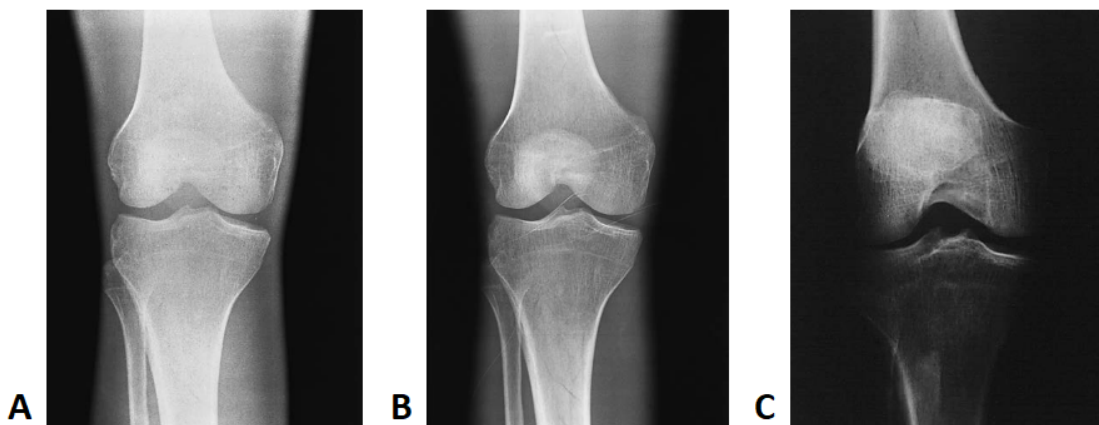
Example of a radiograph with: excessive brightness (A), sufficient brightness (B) and insufficient brightness (C) [2].
